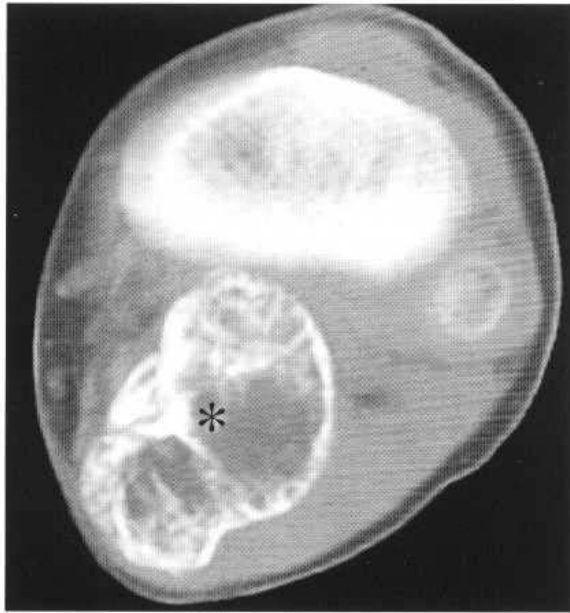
CT Post-traumatic myositis ossificans behind the knee.
